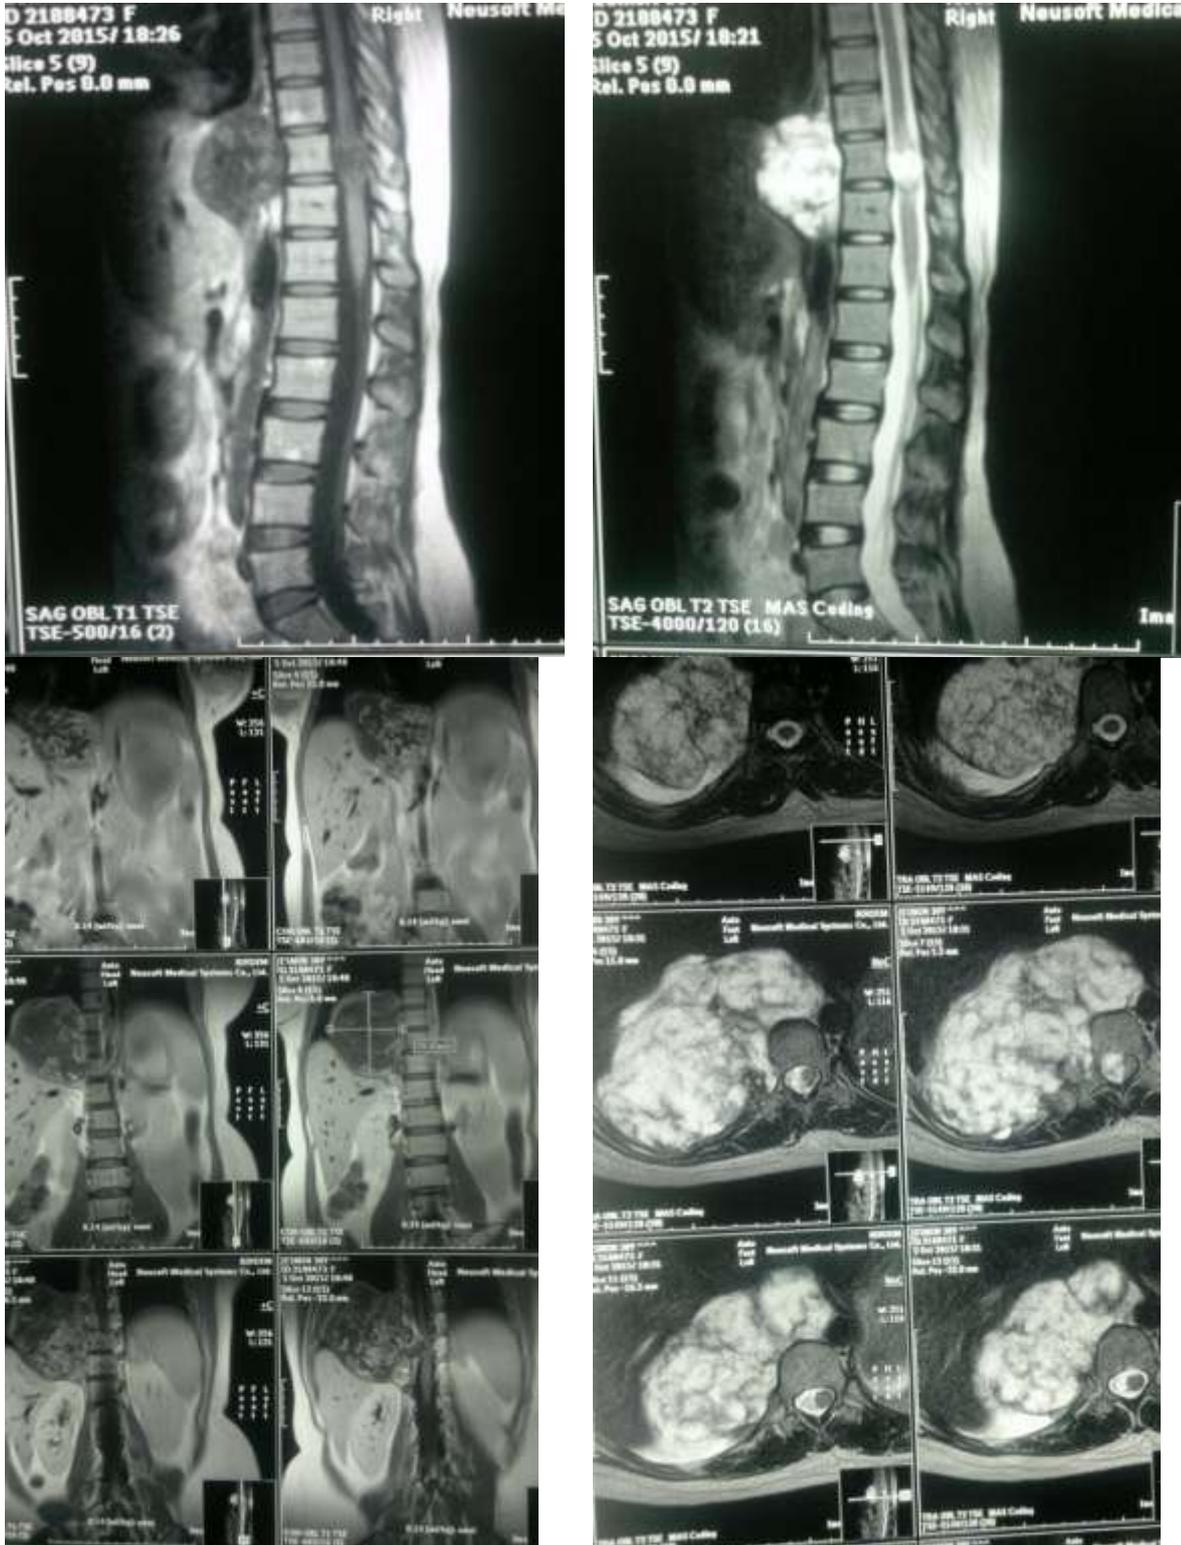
MRI of Dorsal spine (without dye & dye) showing mass (D9-D11)
